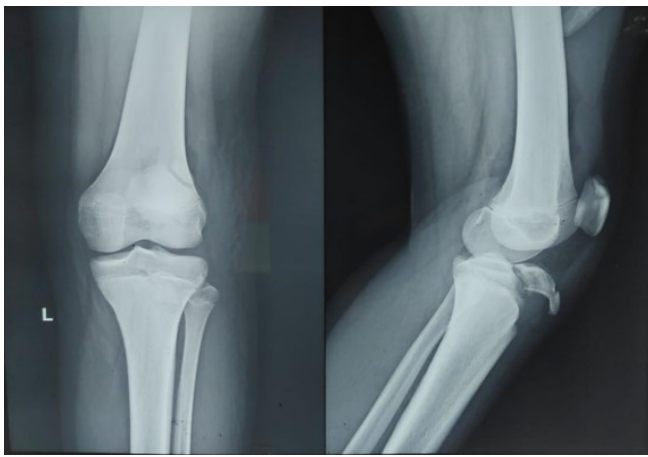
Radiographic image showing the avulsion fracture of the left tibial tuberosity with intra-articular extension post-injury.
